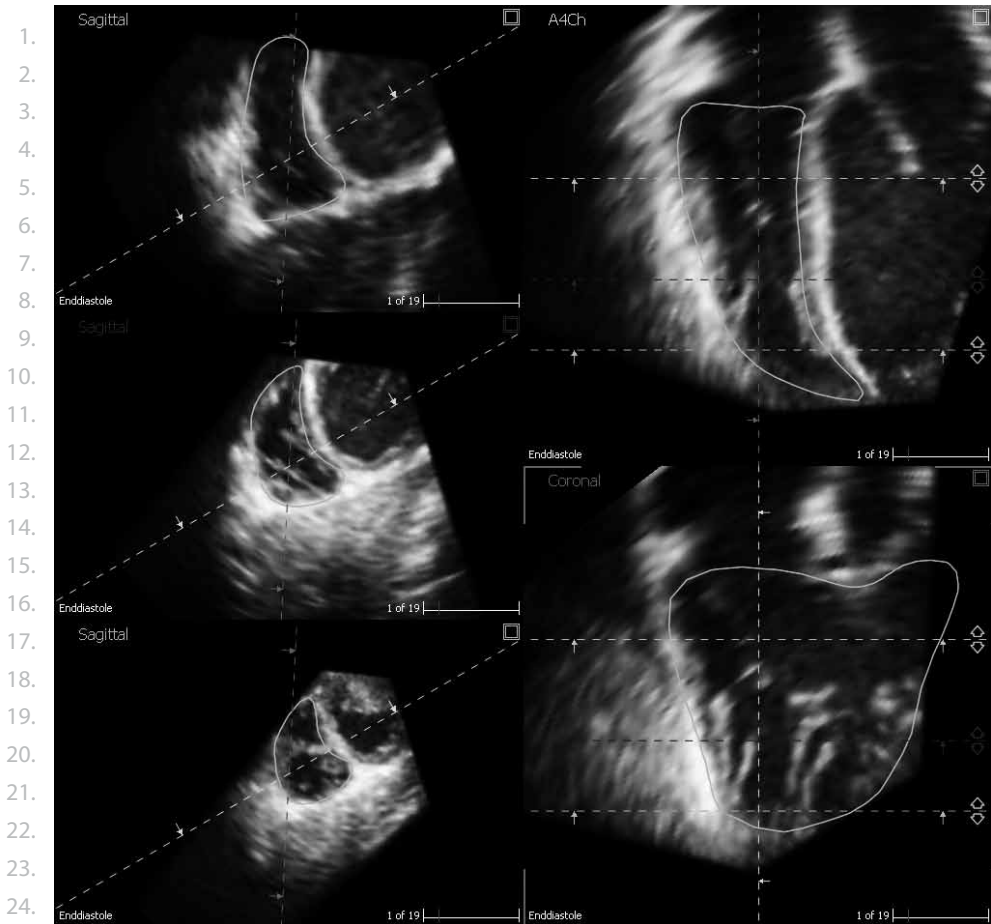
Display from the 4D RV function TomTec analysis program showing the endocardial border contour in the right ventricle at the apical four-chamber view.
